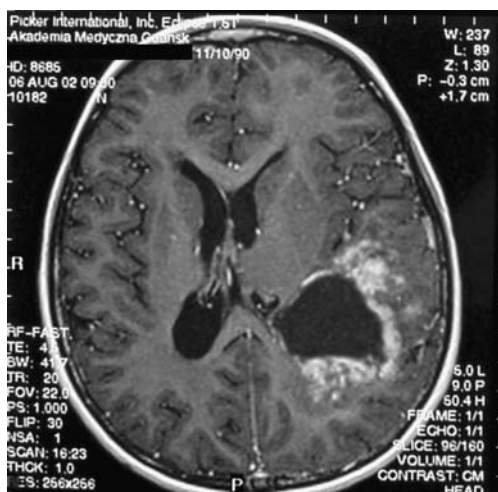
MR of the brain—axial T1-weighted post-contrast image detecting a tumour in the temporo-parietal lobe (patient no. 1)
